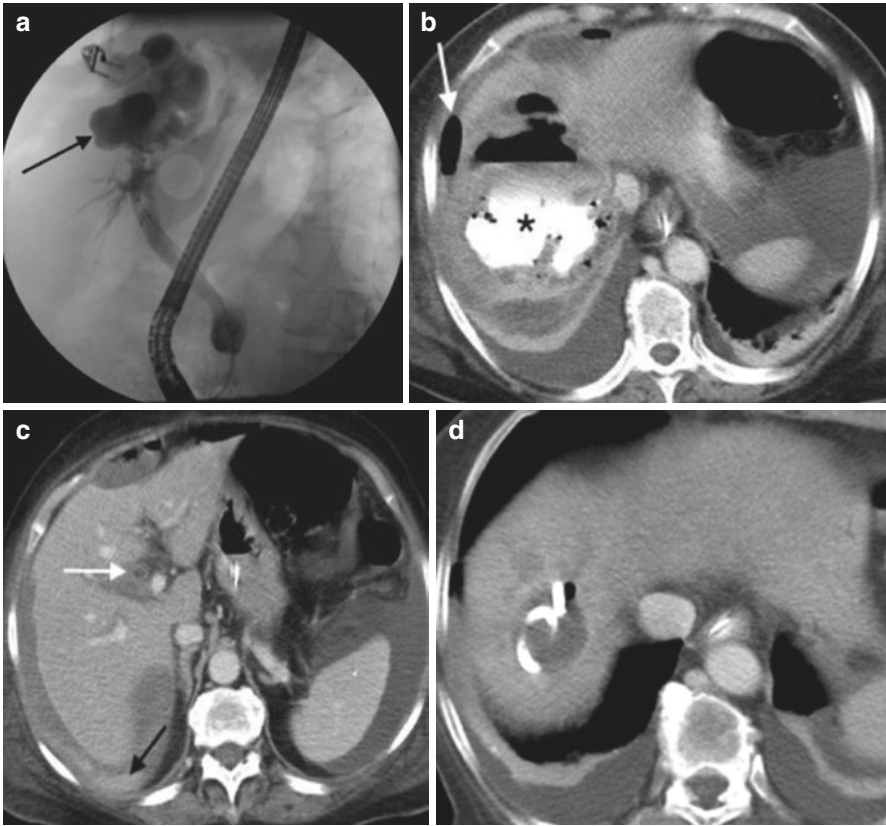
(a) Intrahepatic biloma. Retrograde contrast injection during ERCP reveals a large irregular contrast collection in the liver dome communicating with biliary ductal system (*black arrow*). Purulent drainage from the bile duct at ERCP indicated an infected biloma. Biloma treated with biliary stent. (b) Contrast-enhanced CT performed 1 day later on the same patient revealed retained extravasated contrast injected during ERCP in the biloma (*asterisk*) with free air (*white arrow*). (c) An image more caudally revealed diluted dependent contrast (*black arrow*) and free fluid in the subhepatic space collection from a biliary leak. Bile duct wall enhancement represents cholangitis (*white arrow*). (d) Seven weeks after percutaneous drain placement, the biliary abscess has almost resolved
